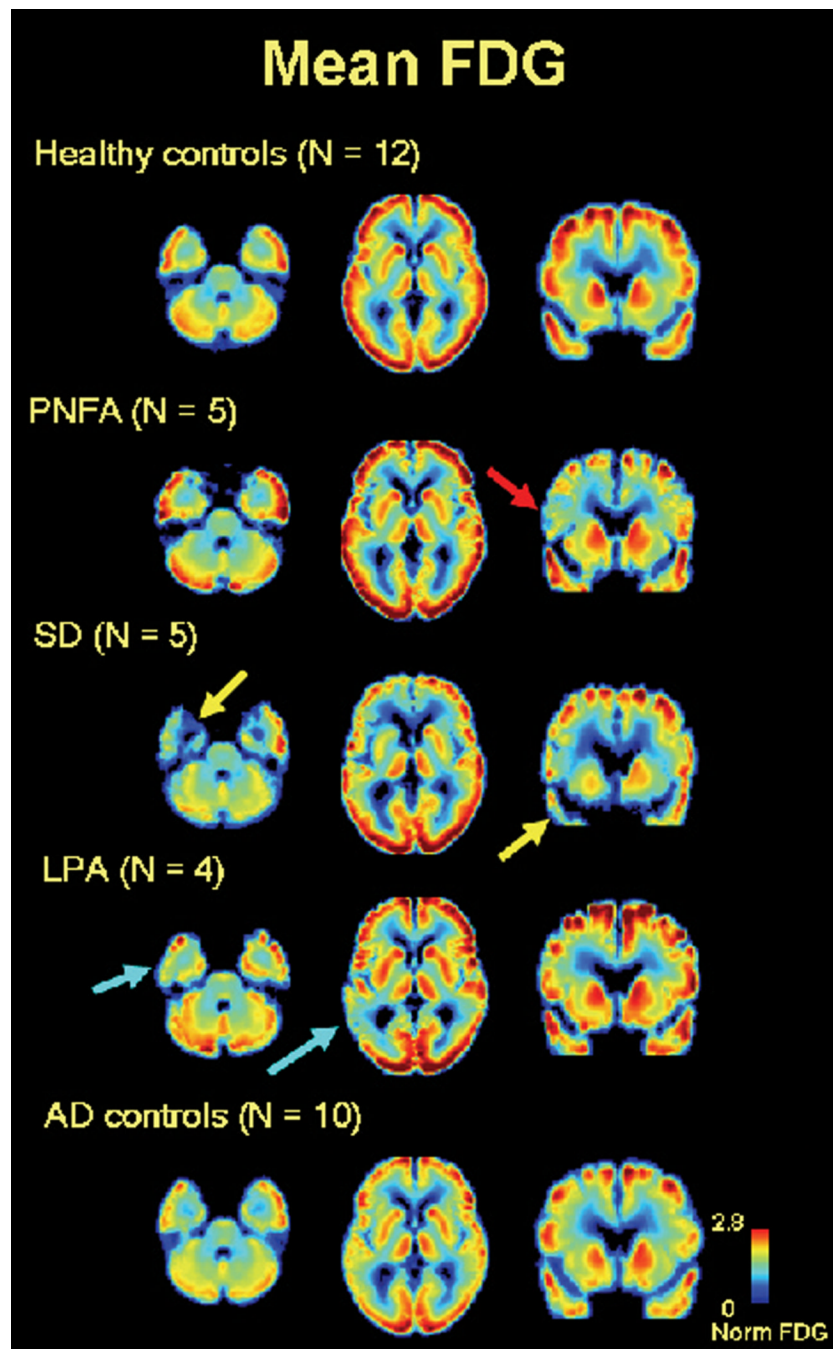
FDG patterns by clinical syndrome. Axial ($z = 9$, $z = 27$) and coronal ($y = 64$) slices of mean atrophy-corrected FDG images from (top to bottom) normal controls (N = 12), PNFA (N = 5), SD (N = 5), LPA (N = 4) and AD (N = 10). Images are in neurological orientation. PNFA is characterized by left frontal hypometabolism (red arrow), SD by left greater than right anterior temporal hypometabolism (yellow arrows), and LPA by asymmetric left temporoparietal hypometabolism (light blue arrows).
